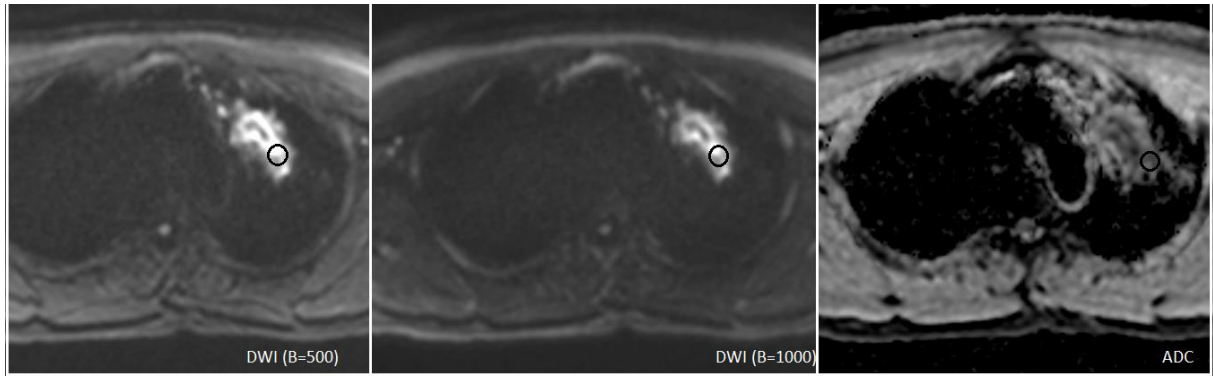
Diffusion weighted images showing peripheral diffusion restriction (hyperintense on DWI with corresponding dark areas on ADC) with central T2W hypointense areas showing no restriction. The values obtained from ROI placed within the solid areas shows the following values.
